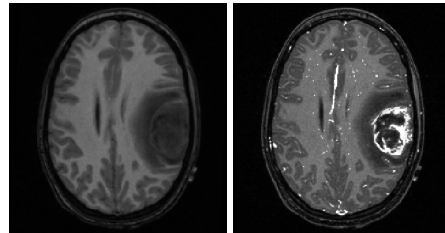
Axial cross-section of T1-weighted 3D MRI, without (left) and with (right) contrast agent.
